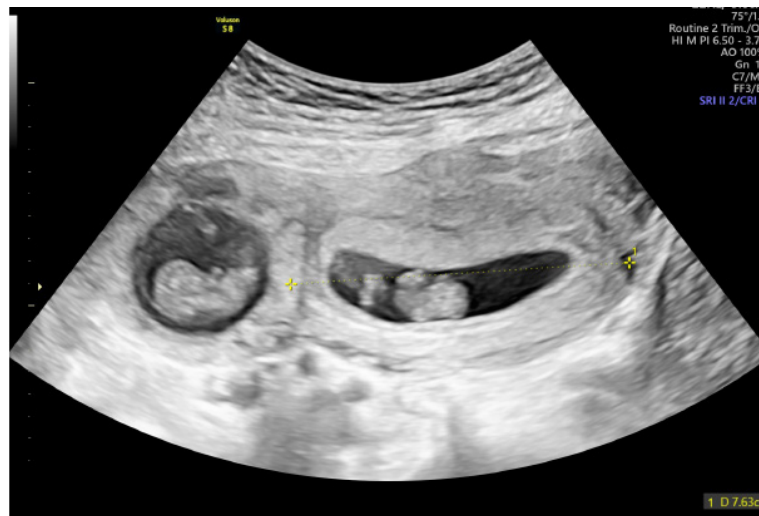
Ultrasonographic features of heterotopic pregnancy. The uterus was anteflexed and slightly enlarged, measuring 12.19 x 7.36 cm. An intrauterine gestational sac (GS) is visible, corresponding to 8-9 weeks; fetal pole (FP) (+) with CRL corresponding to 9-10 weeks; yolk sac (YS) (+) measuring 0.61 cm. A mass is seen at the posterior corpus of the uterus, measuring 2.03 x 1.60 cm. No retro-GS hematoma is visible. No free fluid.
